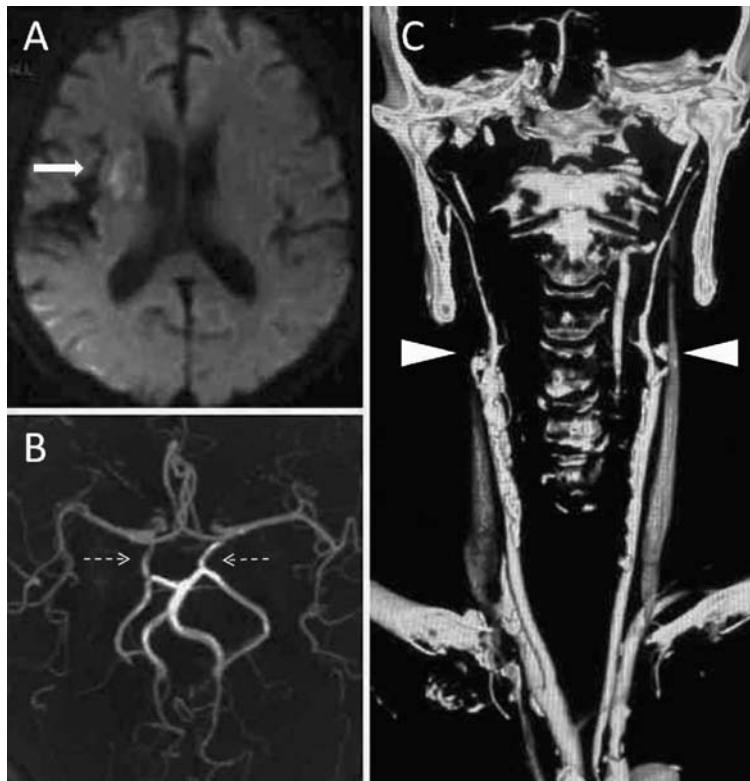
(A) Diffusion-weighted imaging shows high signals in the right hemisphere (arrow). (B) Magnetic resonance angiography reveals the patency of bilateral posterior communicating arteries (dotted arrows). (C) CT angiography shows bilateral internal carotid artery occlusions, moderate stenosis of bilateral external carotid arteries (arrowheads).
